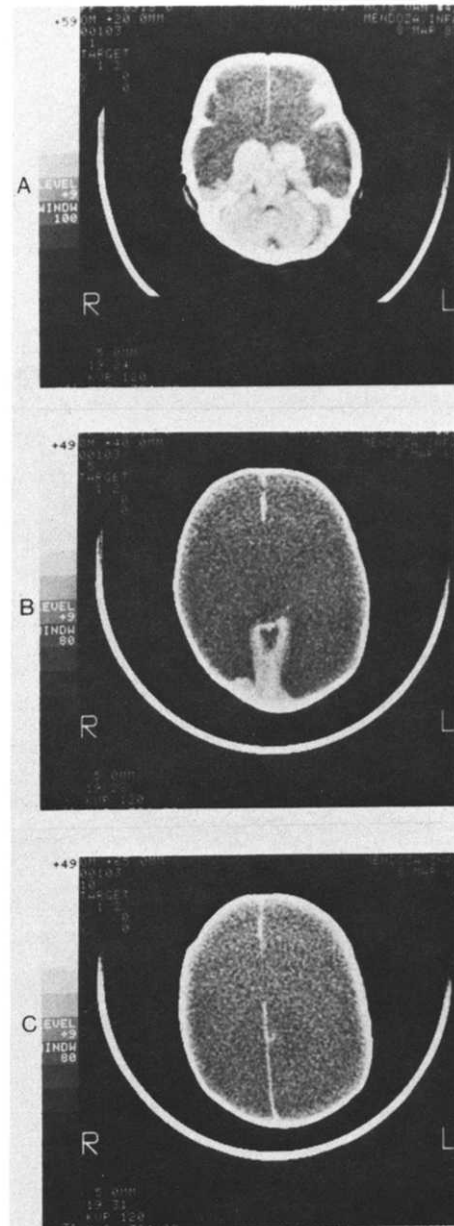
CT scans showing (A) normal cerebellum, pons, and thalamus with large hypodense areas in the anterior and lateral planes representing the replacement of cerebral hemisphere with fluid; (B) the replacement of the cerebral hemisphere with CSF except for a small amount of the temporal lobe; and (C) a complete absence of cerebral hemisphere at this level.
